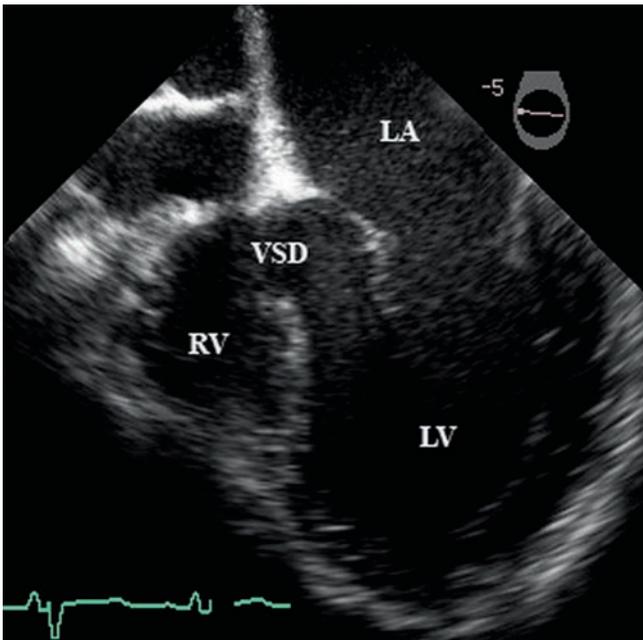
Tricuspid atresia. 4-chamber view obtained at transoesophageal echocardiography in patient with absent right atrio-ventricular connection (tricuspid atresia). The left atrium (LA) connects through the mitral valve to the left ventricle (LV). No atrio-ventricular valve is discernable on the right and the absent connection is seen echocardiographically as an echogenic border between the right atrium and small right ventricle (RV). The posterior aspect of ventricular septal defect (VSD) is seen and is non-restrictive
